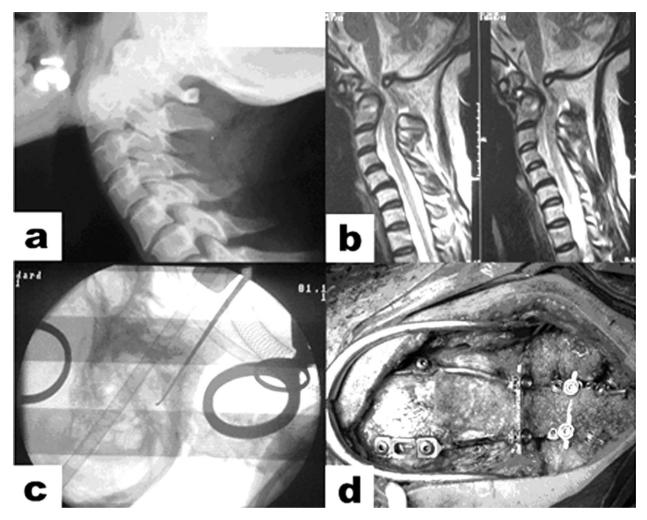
A 59 years old female admitted to our emergency department with the complaint of neck pain after a motor vehicle accident. Neurological examination revealed right global hemiparesia with motor power of 4/5. The plain X-ray (a) and cervical MRI sections (b) revealed a type II odontoid fracture causing severe the spinal cord compression anteriorly. A halo vest was placed in the operating room and she underwent transoral resection of the odontoid and posterior occipitocervical fusion in the same session. A peroperative fluoroscopy view after transoral resection and intraoperative photo after occipitocervical fixation are shown in figures (c) and (d) respectively.
